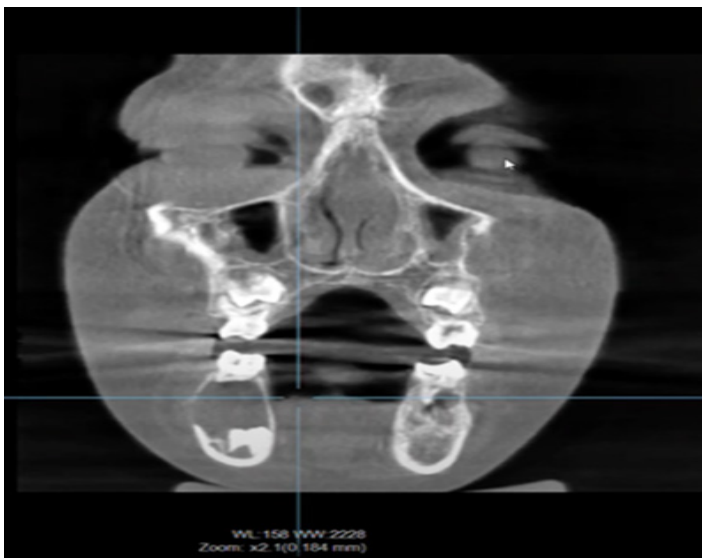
Pre-Operatif CBCT Coronal Section
